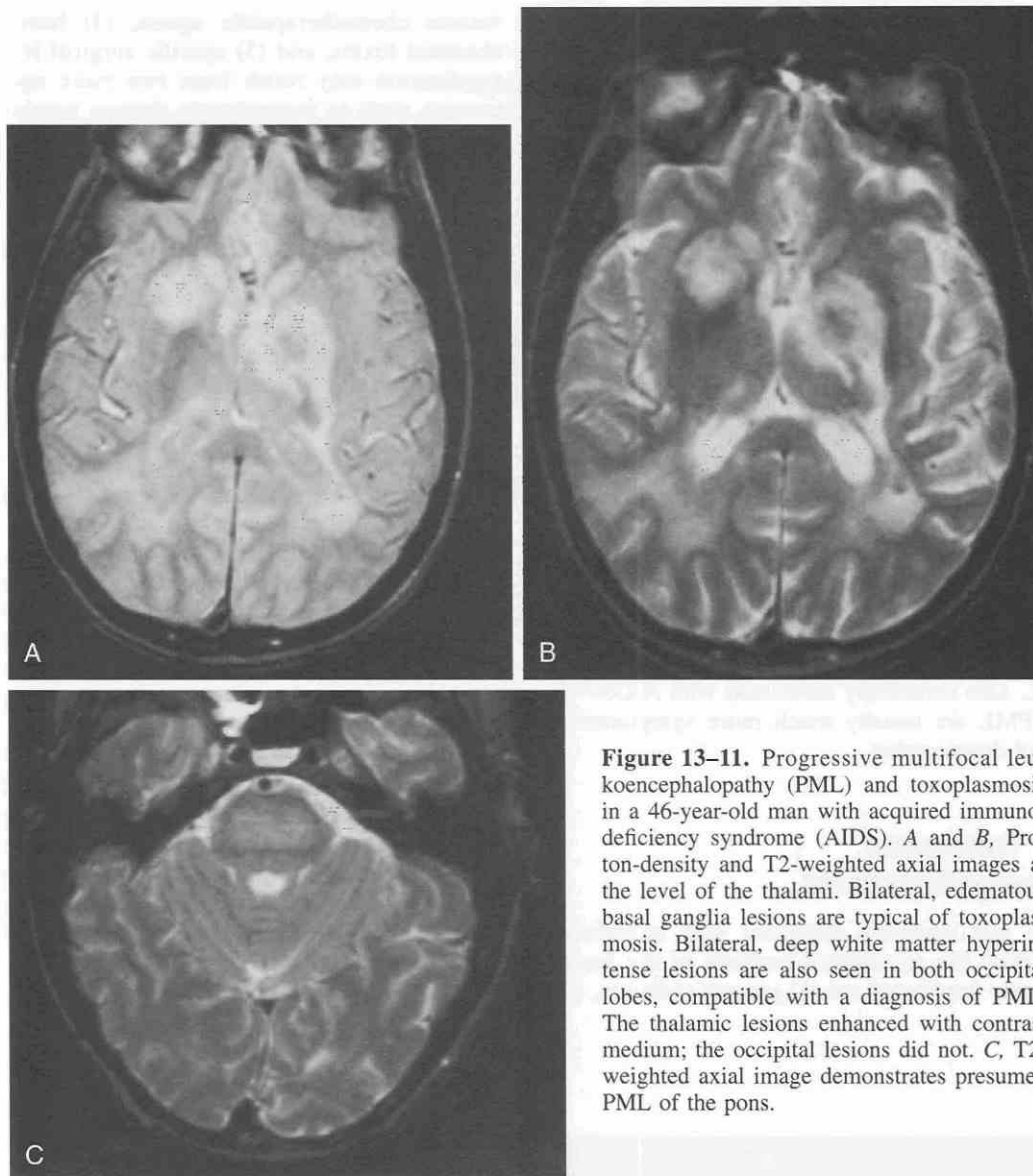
Progressive multifocal leukoencephalopathy (PML) and toxoplasmosis in a 46-year-old man with acquired immunodeficiency syndrome (AIDS). A and B, Proton-density and T2-weighted axial images at the level of the thalami. Bilateral, edematous basal ganglia lesions are typical of toxoplasmosis. Bilateral, deep white matter hyperintense lesions are also seen in both occipital lobes, compatible with a diagnosis of PML. The thalamic lesions enhanced with contrast medium; the occipital lesions did not. C, T2-weighted axial image demonstrates presumed PML of the pons.
